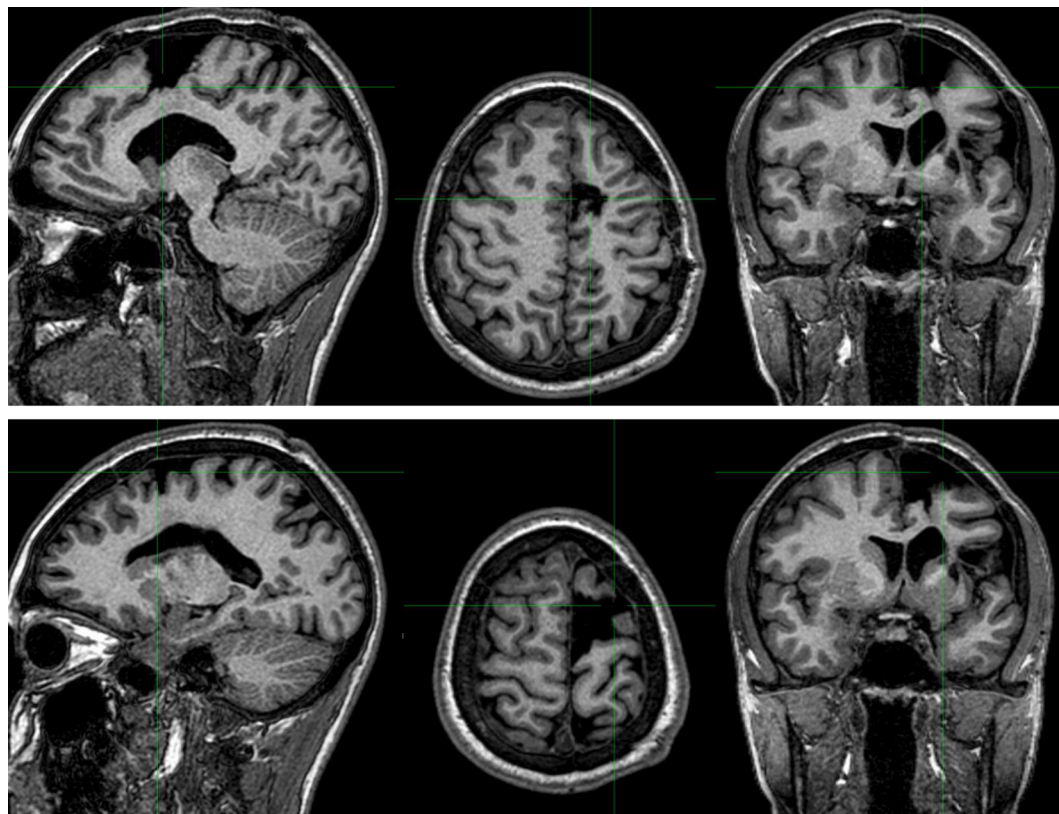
Post-operative MRI performed 6 months after surgery: 3D-T1 (sagittal, axial, coronal planes) showed the detailed of the surgery consisting in a left pre-central parasagittal cortectomy.
